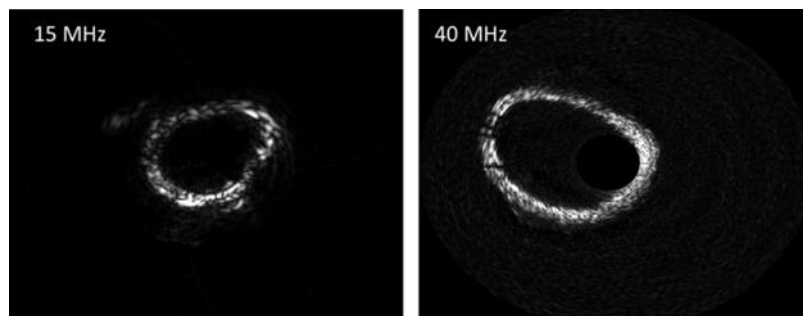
Representative image of the vessel using 9F/15MHz and 4.5F/40MHz catheters. Higher central ultrasound frequency of the 4.5F/40MHz catheter allows imaging with finer details compared to 9F/15MHz catheter.
